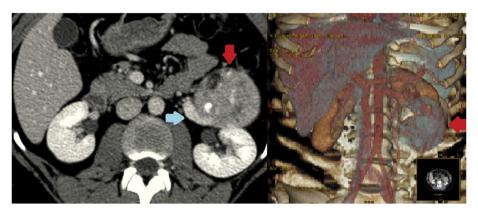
Angiotomography and CT scan.
